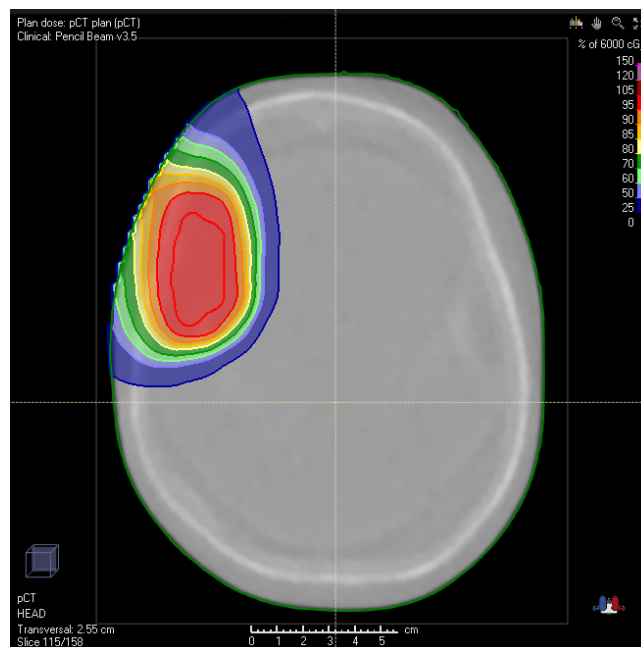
Open source proton therapy planning for CT and pCT.*
